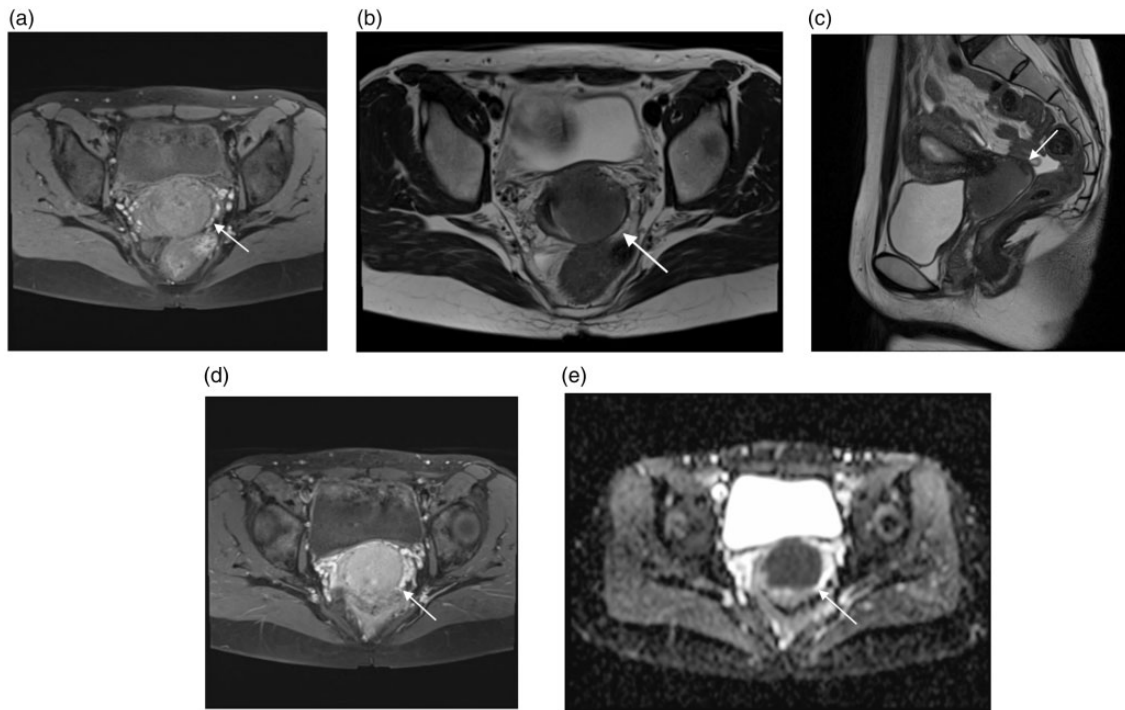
Contrast-enhanced MRI: (a) axial fat-suppressed T1W images, (b) axial T2W images, (c) sagittal T2W images, (d) contrast-enhanced fat-suppressed T1W images, (e) ADC map. T1W and T2W images showed an isointense mass confined to the cervix, and contrast-enhanced fat suppressed T1W images revealed homogeneous enhancement. The ADC map showed strongly restricted diffusion ($0.43 \times 10^{-3} \text{ mm}^2/\text{s}$).
